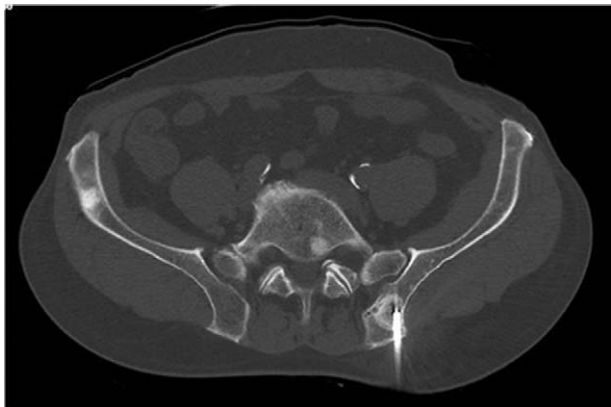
Computed tomography (CT)-guided bone biopsy: CT-guided needle biopsy of the 22-mm oval-shaped sclerotic bone lesion located at the left iliac crest, close to the sacroiliac synchondrosis.
